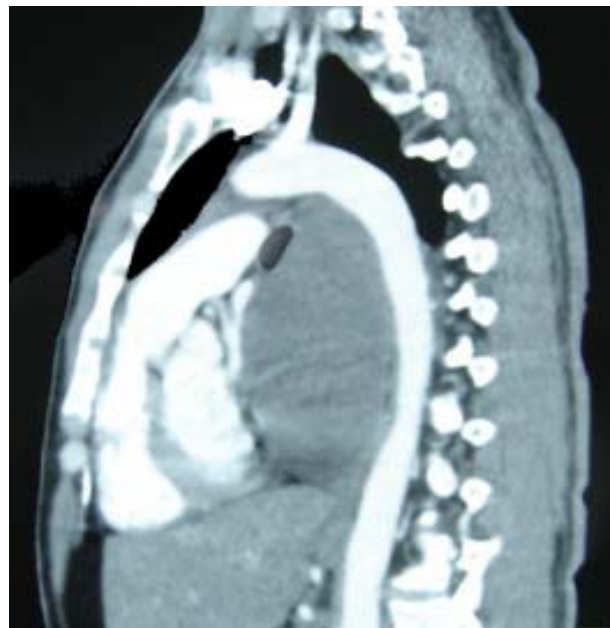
CT scan of the thorax showing the cyst.
